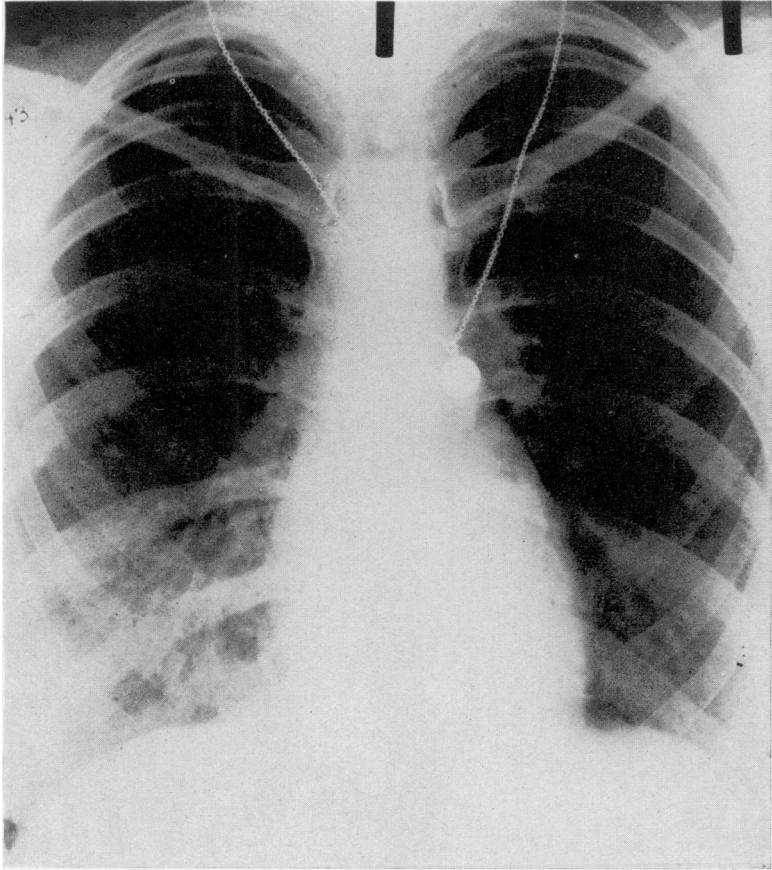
X-ray picture of chest of Case 19 on fifteenth day of illness.
